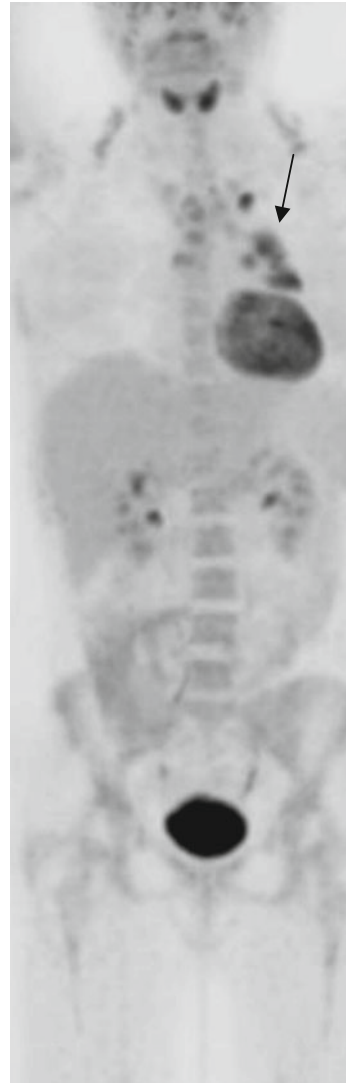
PET/CT after 6 cycles of BEACOPP-escalated. Final response assessment revealed a 7 cm residual mediastinal lesion with persistent abnormal 18-FDG uptake (SUV max 5) on PET/CT, corresponding to a D5-PS score 4
